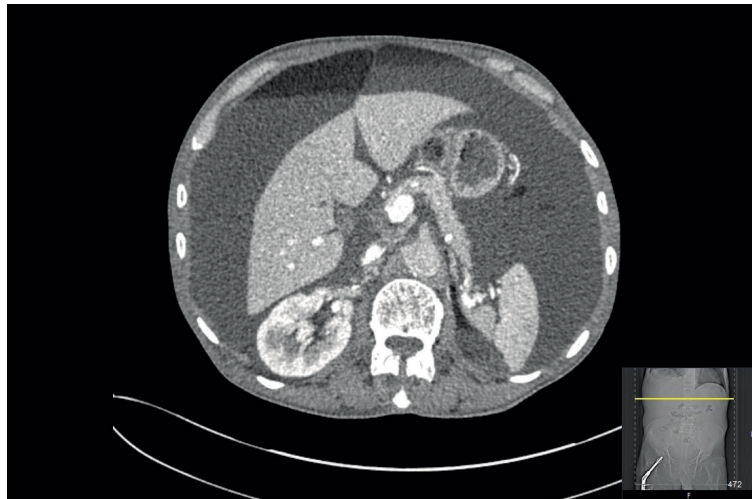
An axial computed tomography scan showing chylous ascites.
